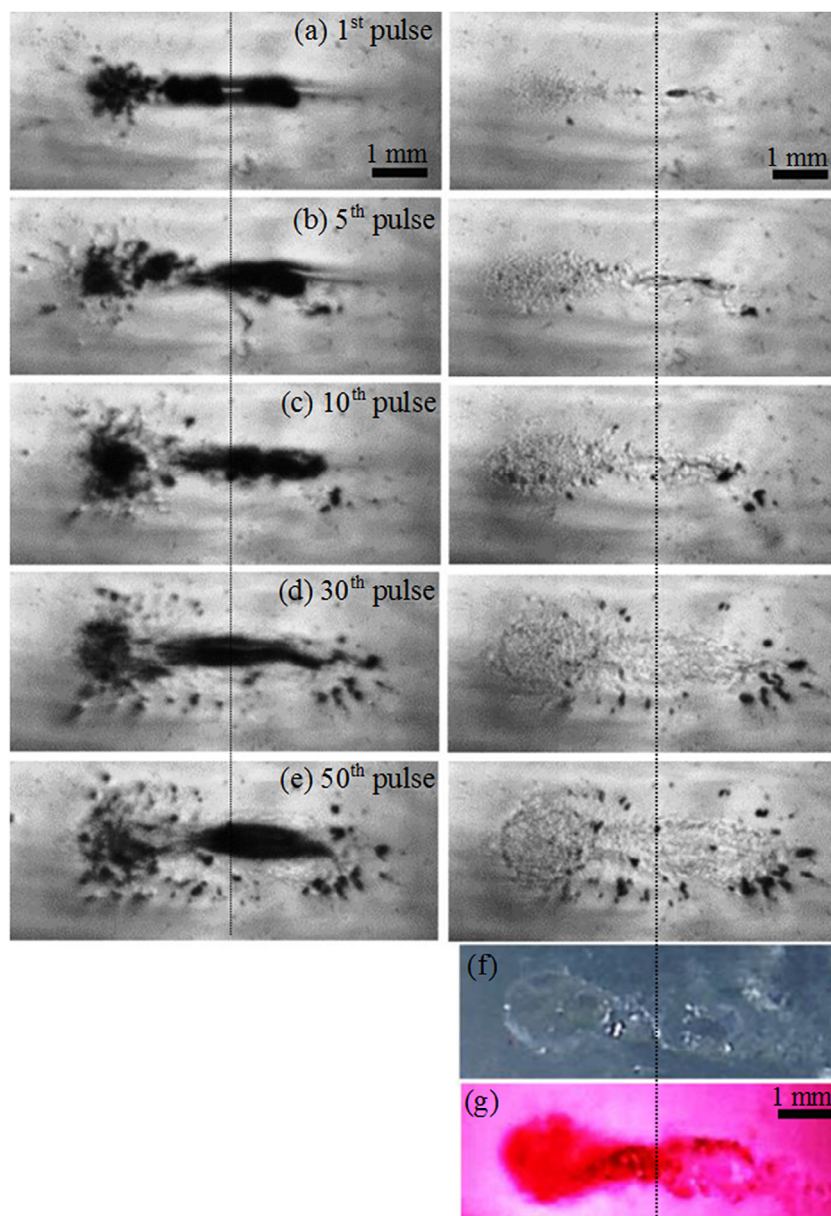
High-speed images taken over the course of 50 HIFU pulses (a–e). (f) Cross-sectioned lesion after the 50th HIFU pulse and (g) the same lesion as (f), but with an added dye. An acquisition rate of 1000 fps was used. Bubble activity at the end of each 10-ms HIFU pulse (*left column*) and the corresponding mechanical damage induced in the gel (*right column*), which were taken at 1 ms (*i.e.*, 1 frame) before the arrival of the next HIFU pulse. The HIFU beam propagates left to right. The vertical dashed lines pass through the HIFU focal point perpendicular to the beam axis. HIFU = high-intensity focused ultrasound.
